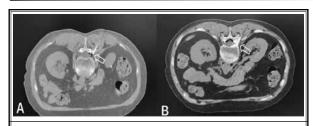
TFESI technique as demonstrated in a 73-year-old woman with low back pain. A) Computed tomography fluoroscopy image demonstrates the needle advanced into the epidural space. The white arrow shows the needle path. B) One mL of contrast medium was injected into the epidural space. The white arrow shows the contrast medium.
